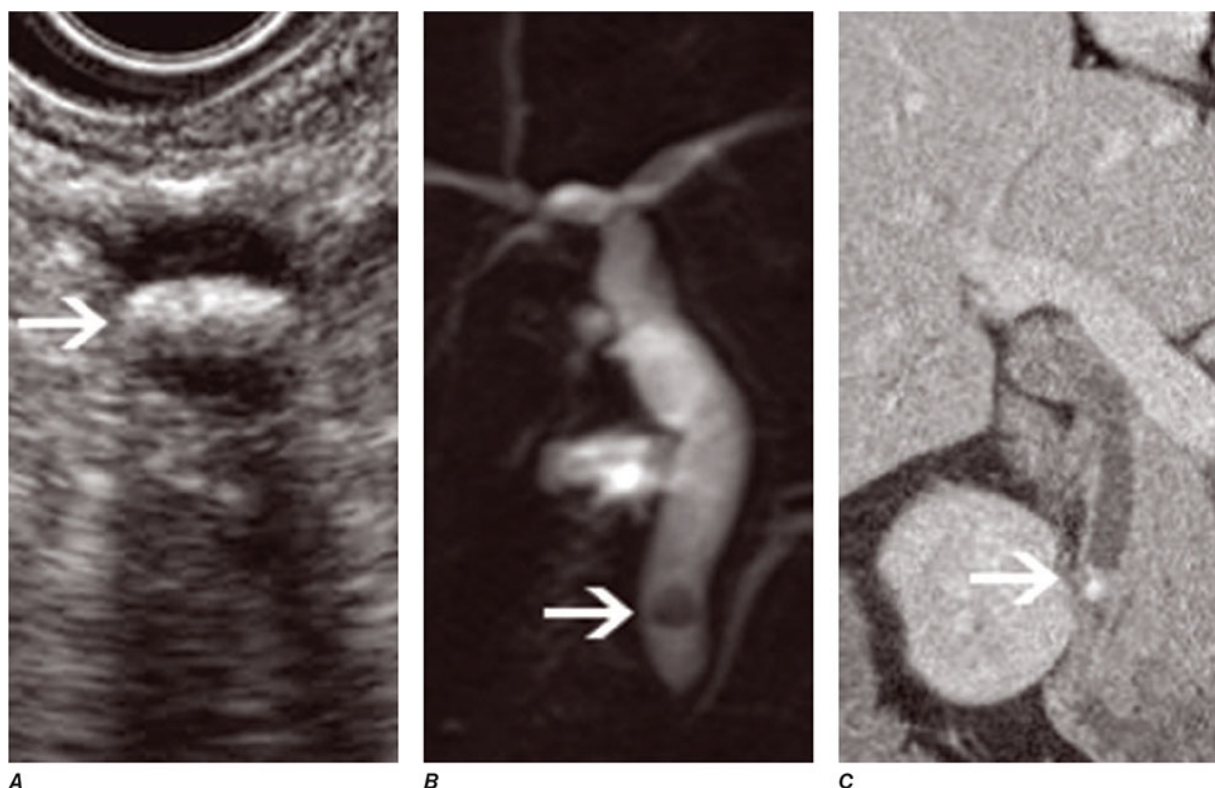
Methods of bile duct imaging. Arrows mark bile duct stones. A. Endoscopic ultrasound (EUS). B. Magnetic resonance cholangiopancreatography (MRCP). C. Helical computed tomography (CT).
